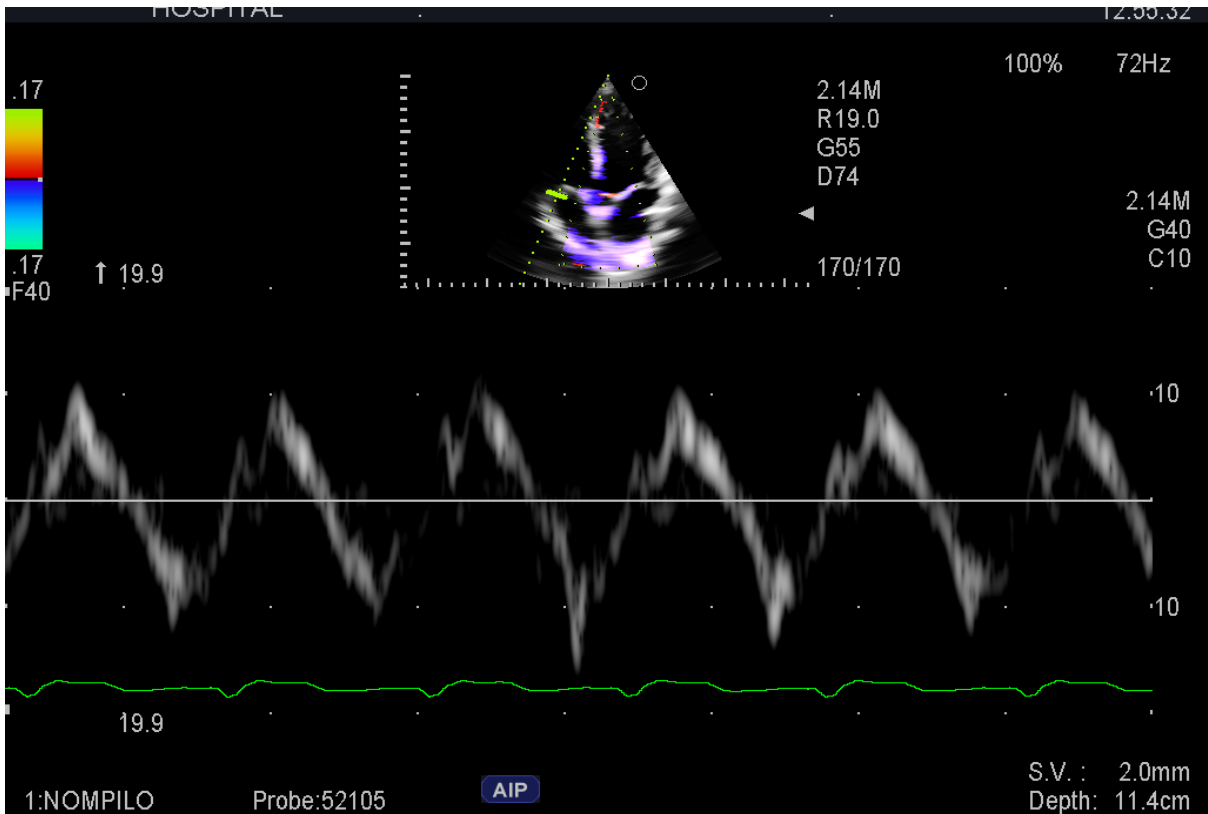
Pulsed Doppler of the tricuspid inflow, tissue Doppler of the lateral tricuspid annulus.
